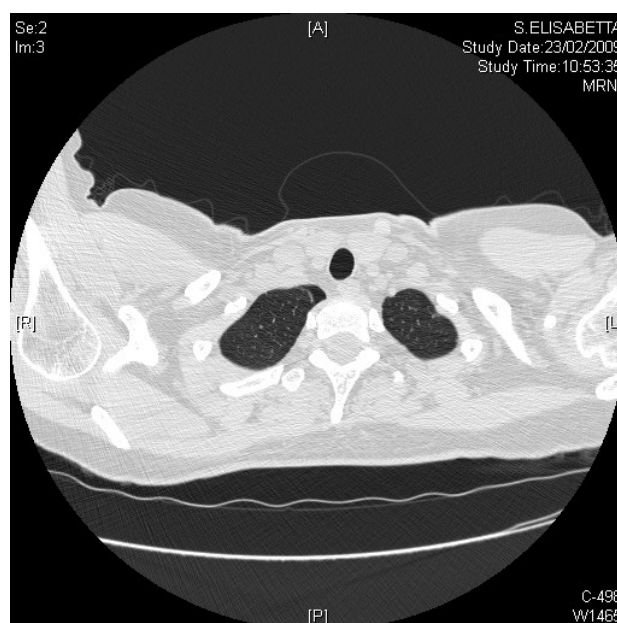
Catamenial pneumothorax: chest CT scan showing almost undetectable right pneumothorax one month after pneumothorax resolution (first episode).
